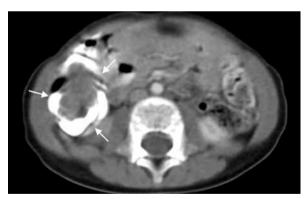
Intussusception and cecal duplication cyst at the right upper quadrant of the abdomen on the axial contrast-enhanced CT (Arrows: Cyst and Intussusception).
